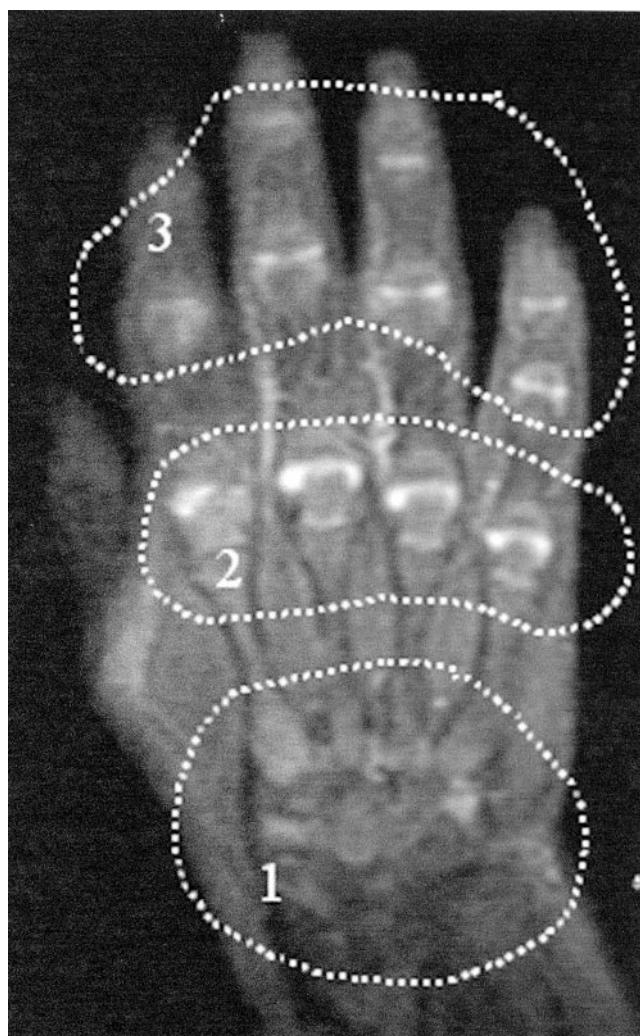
Three regions of interest outlined on a fat suppressed coronal T1-weighted image of the hand following intravenous contrast administration: 400/14 (repetition time, TR, ms/echo time, TE, ms), 4/1 (slice thickness mm/gap thickness mm), 256 × 160 matrix, 20 cm field of view (FOV). Region 1 includes the distal radiocarpal and carpal-proximal metacarpal joints; region 2 includes the distal metacarpal-phalangeal joints; region 3 includes the proximal and distal interphalangeal joints.
